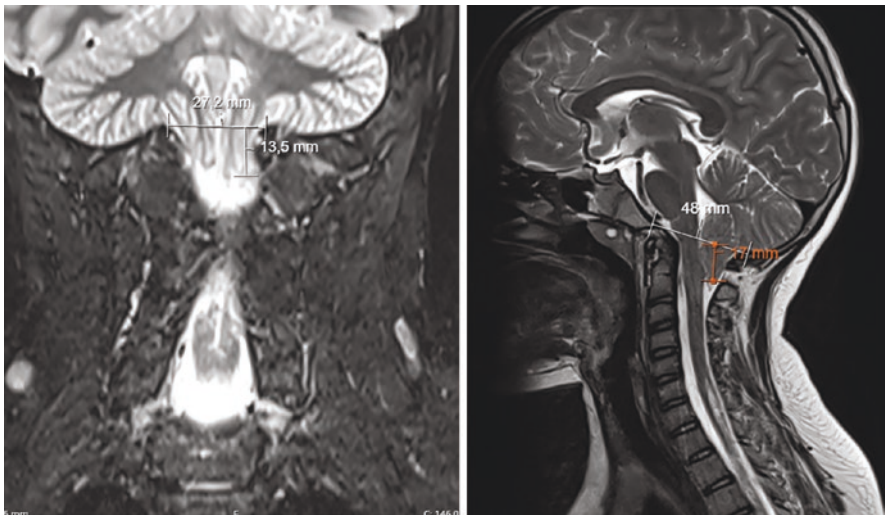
MRI with T2 sagittal and coronal plane demonstrating the measurement of tonsillar ectopia in a Chiari type I malformation patient (13.5 mm on coronal plane, 17 mm on sagittal plane)
